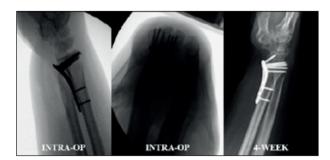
Intra-operative and 4-week follow-up x-ray
